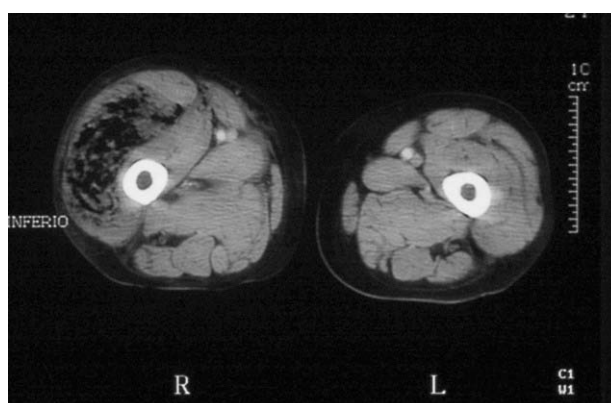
CT scan of lower limbs at the level of the union of the middle and proximal third of the thigh. Gas bubbles are observed dissecting the vastus lateralis muscle and producing a curving of the fascia lata towards the distal end of the thigh.
